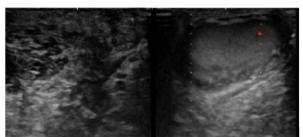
Ultrasound testicles showing cystic lesions in scrotal wall and a normal testis.
